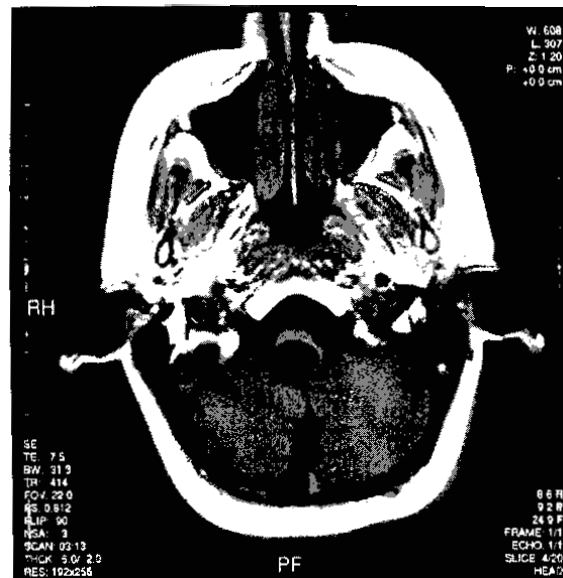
Case 1 at language testing (18 months post treatment)*: T1 weighted coronal MRI scan of the brain post-radiotherapy demonstrating a cystic astrocytoma in cervicomedullary junction.
